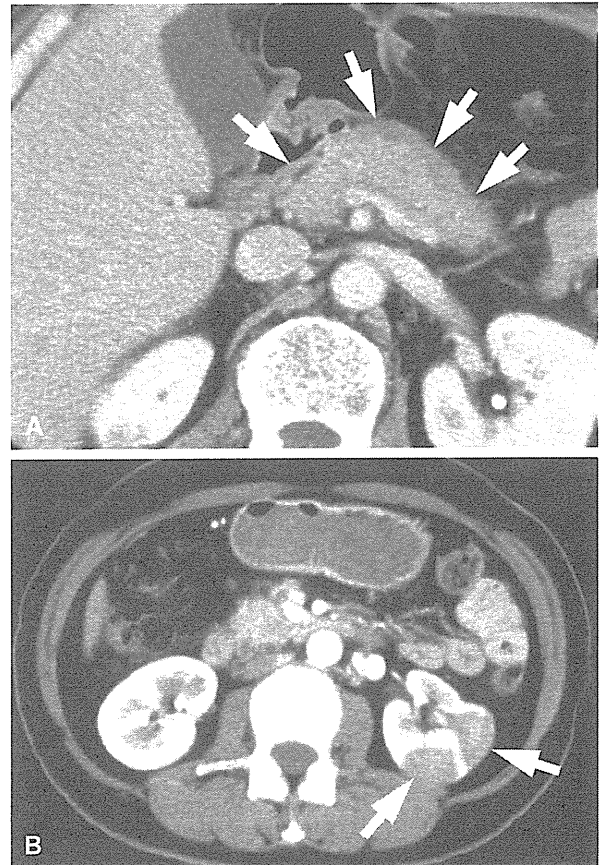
Systemic organ involvement. Postcontrast axial computed tomography demonstrates involvement (arrows) of the pancreas (A) and kidneys (B).
